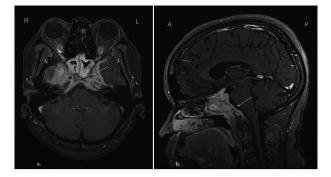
a) MRI head T1 weighted post contrast axial slice. After termination of corticosteroids, MRI demonstrates significant hypertrophy of skull base lesion with further compression of internal carotid arteries in cavernous sinuses (arrows). b) MRI head T1 weighted post contrast saggital slice in midline. After termination of corticosteroids, MRI demonstrates mass extending from skull base into pituitary fossa, through sphenoid sinus and into nasopharynx. Involvement of posterior clivus is clear (arrow).
